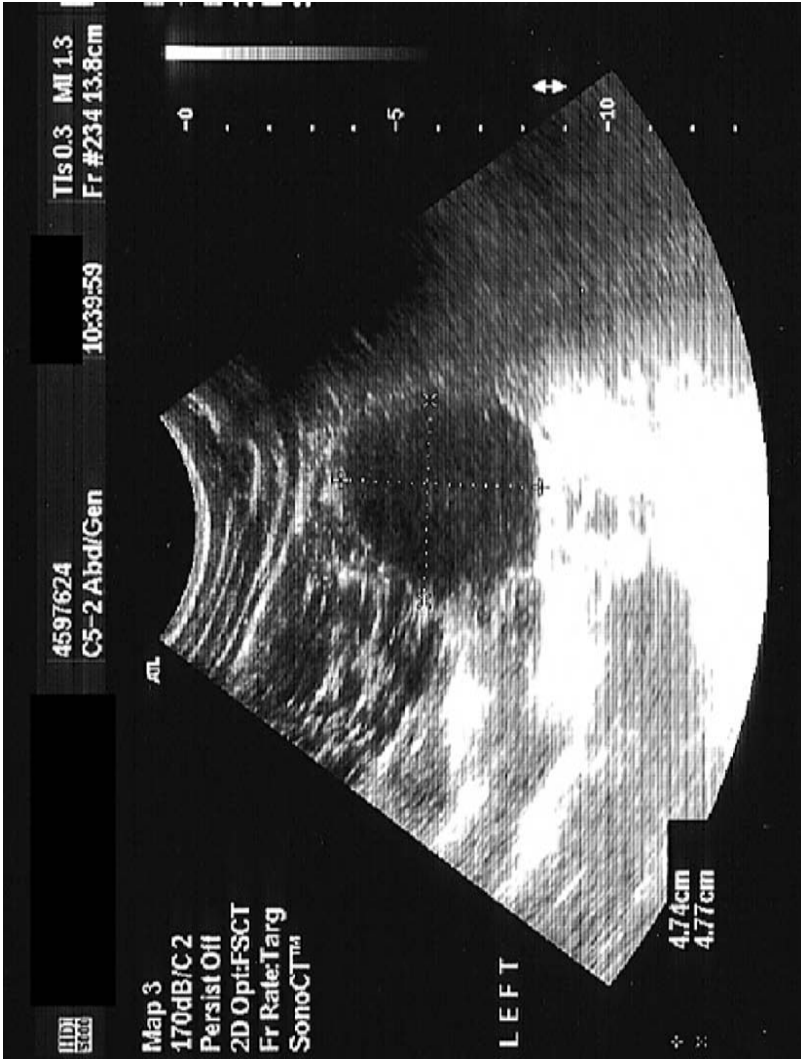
Ultrasound picture of right kidney. Reproduced with permission of the patient and the radiologist.
